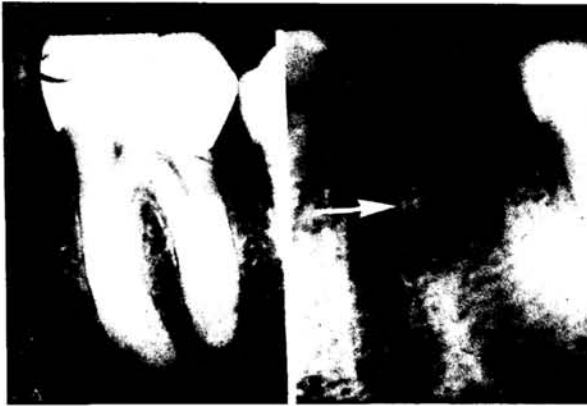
a case of alveolgia ("dry socket"). X-rays of a molar prior to extraction (A), and its socket one week following the extraction (B) exhibiting "ghost imaging" and bony osteitis (arrow).
